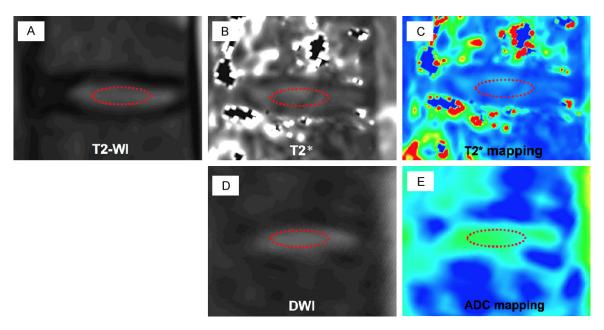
Representative MRI processing and region of interest (ROI) selection. (A) T2-WI image of T2-T3 was obtained from a 43-year old male patient with a red ellipse ROI placed in the middle of the disc to define the nucleus pulposus. The present disc was classified as grade III according to the Pfirrmann grading system with inhomogeneous morphological structure, slightly decreased disc-height, and intermediate signal intensity, which was unclear to distinct between the nucleus and the anulus. The ROI was then copied from the T2-WI image and pasted onto the identical position of the disc on T2\* image (B), T2\* colored mapping (C), DWI image (D), and ADC colored mapping (E).
